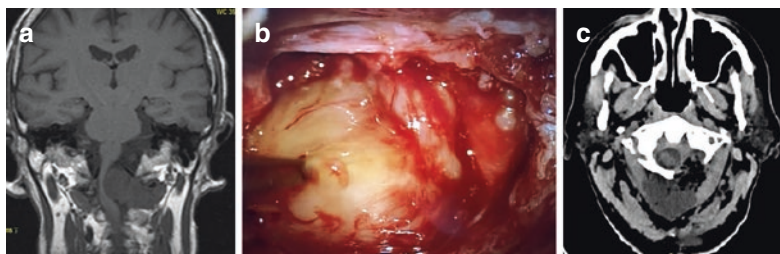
(a) Coronal non-contrast T1-weighted MRI image showing a case of large intra/extracranial schwannoma C2 on the left side in a 68-year-old patient with a 6-month history of pain and progressive tetraparesis. (b) Intraoperative image of the same case displaying the exposed schwannoma, which was removed via a C1 hemilaminectomy in a semi-sitting position. (c) Axial computed tomography scan performed on the first postoperative day demonstrating the left hemilaminectomy of the atlas and total removal of the lesion
